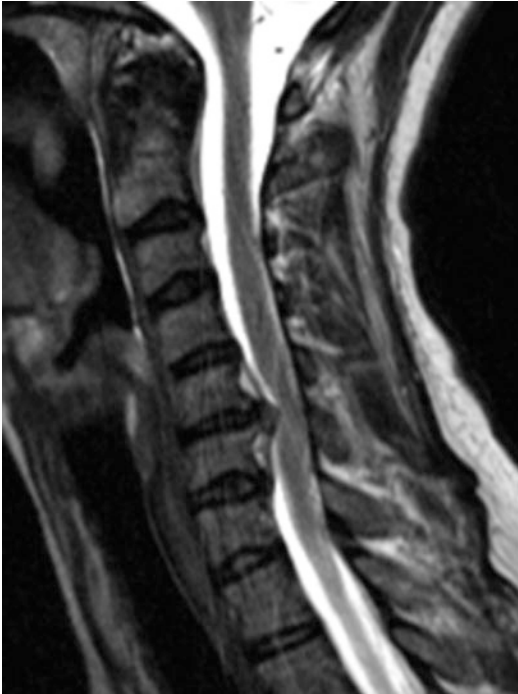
The MRI scan of the cervical spine in the sagittal plane shows a large soft disc herniation at the level C5/6
